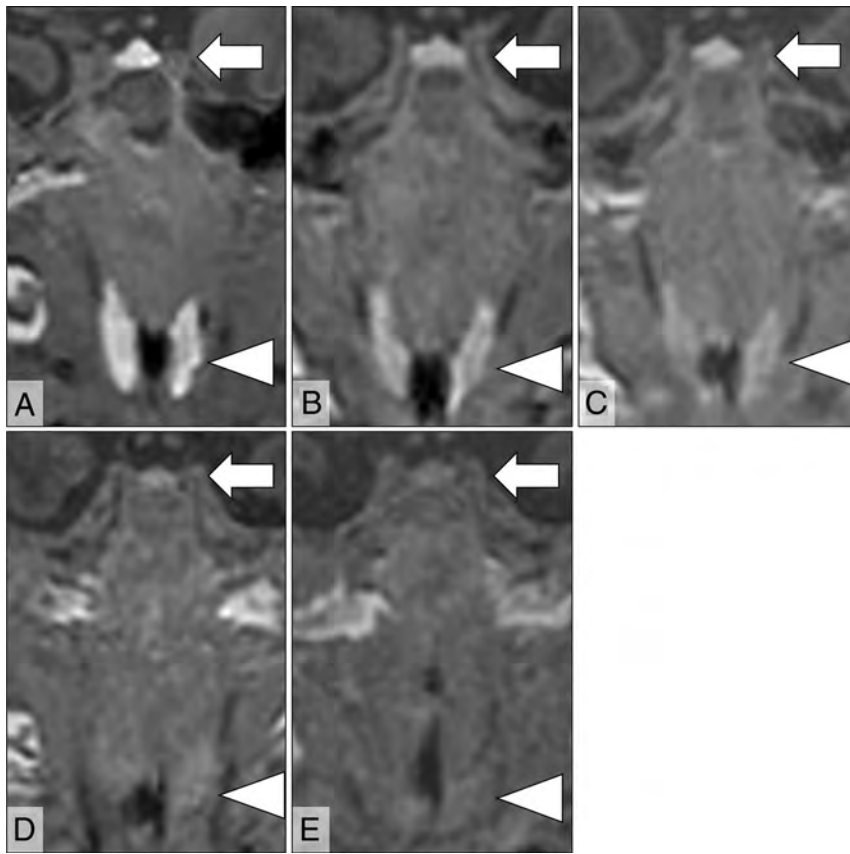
Five different cases showing the thyroid (arrowheads) and anterior pituitary (arrows) on coronal 3D GRE T1-weighted MR images examined at different postnatal ages: 4 days (A), 21 days (B), 33 days (C), 46 days (D), and 70 days (E). These patients' gestational ages at birth are 41, 34, 31, 31, and 29 weeks, respectively. At 4 days of postnatal age, the thyroid and anterior pituitary show extremely high signal intensity (A), and the signal intensity of those glands decreased proportionally to postnatal age (B–E). The signal intensities of the thyroid glands are similar to those of the anterior pituitary glands regardless of postnatal age, and the thyroid–anterior pituitary signal intensity ratios are almost 1 (A = 0.91, B = 1.04, C = 0.83, D = 0.81, E = 0.92).
